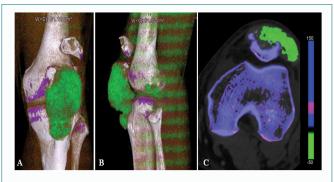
Dual-energy CT scan detecting monosodium urate deposits (green) in the left knee. (A, B) 3D reconstruction showing tophaceous gout enveloping the inferior component of the fractured patella. (C) Axial cut through the inferior component showing lytic erosion of tophus centrally within the patellar bone.
